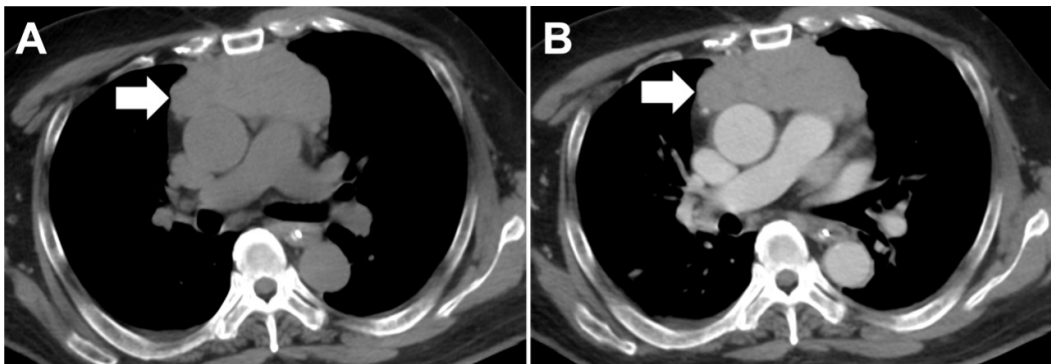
A male patient in his 50 s with thymoma (WHO type B3) with MG. Axial (a) unenhanced CT and (b) contrast-enhanced CT showing lower tumor contrast enhancement (17.8 HU) (arrows).
